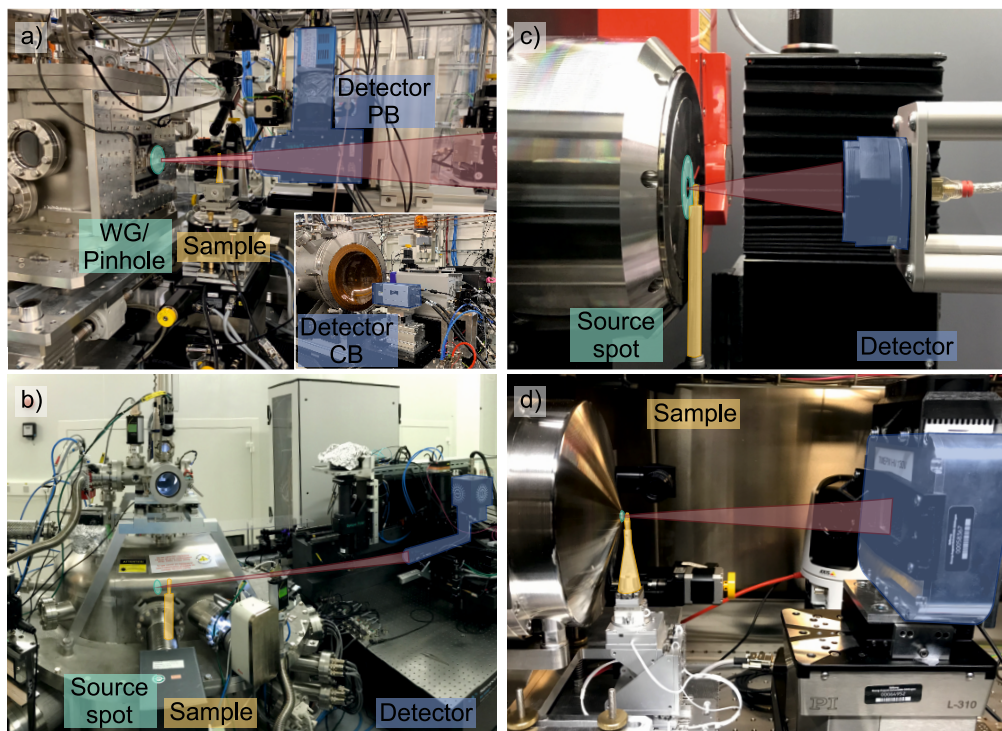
Annotated photographs of the experimental setups. (Green) marks the X-ray focal plane, (orange) the sample stage, (blue) the detectors. (a) GINIX endstation at P10 beamline, DESY, Hamburg (SR1). In PB-configuration, the PCO.Edge-detector is used ("Detector PB"). The inset shows the detector stage approx. 5 m down stream ("Detector CB" sCMOS-cameras, Photonic Science & Andor). (b) ID16A beamline, ESRF, Grenoble (SR2). (c) EasyTom Nano setup (RX Solutions), with the CCD-camera in use (μ CT1). (d) Home-built nanoPC-CT setup TiNa, with Excillum NanoTube N2 X-ray source and a single photon counting detector (Timepix) (μ CT2).
